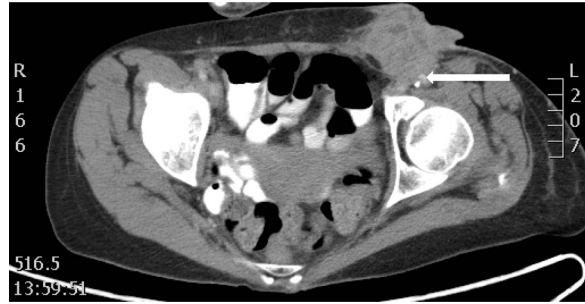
Axial cut, contrast-enhanced computed tomography scan demonstrating protrusion of a neoplastic mass with circumferential encasement of and impingement on the left distal common femoral artery (solid white arrow).
